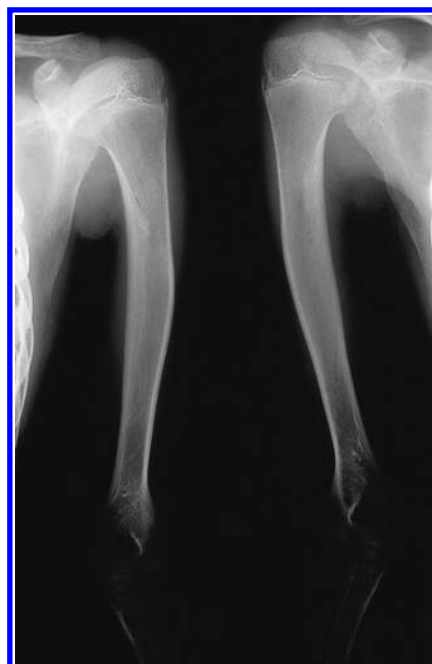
Roentgenogram of the humeri of a 12-year-old girl with homocystinuria revealed osteopenia and lateral bowing.
